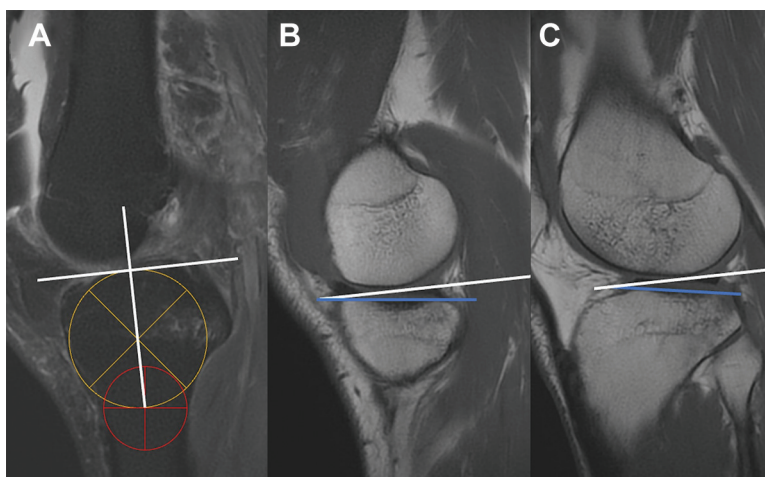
The methods for measuring medial and lateral tibial slopes in MRI. (A) The longitudinal axis was defined by the line between the cranial circle and the caudal circle. (B) The medial slope was measured by the angle between the tangent line of the medial plateau (blue line) and the vertical line to the longitudinal axis. (C) The lateral slope was measured by the angle between the tangent line of the lateral plateau (blue line) and the vertical line to the longitudinal axis. MRI, magnetic resonance imaging.
